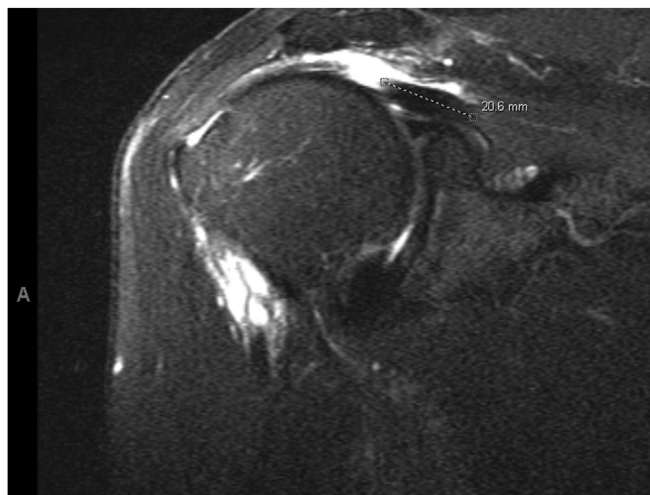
Image demonstrating measurement of residual tendon length on muscle on coronal T2 right shoulder MRI. MRI, magnetic resonance imaging.
